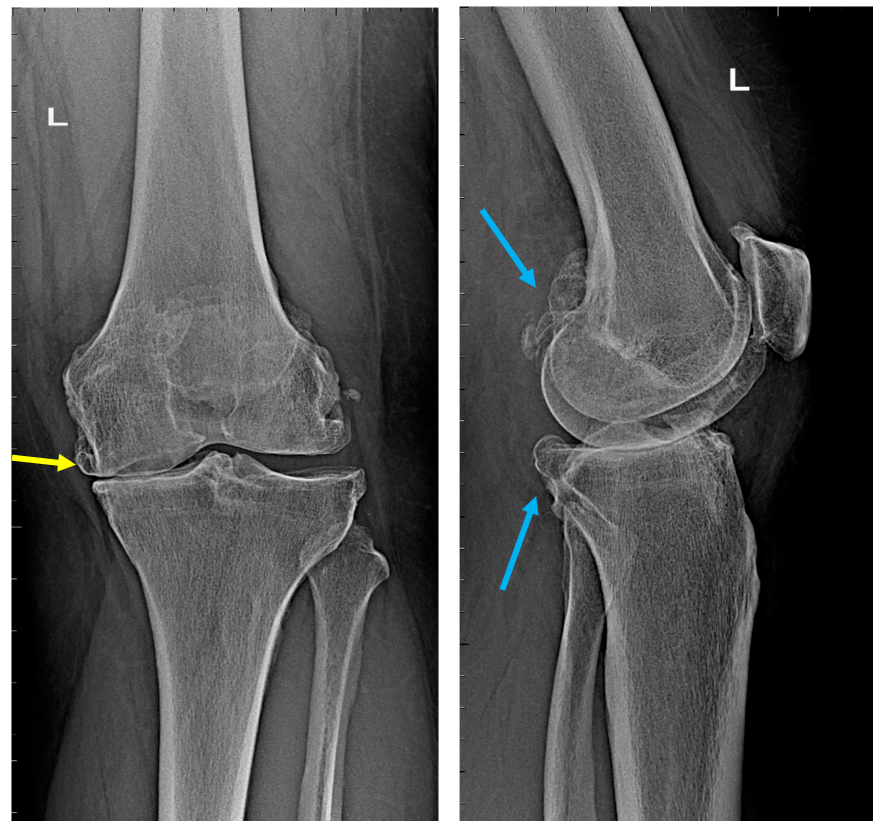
Radiographs of the knee joint. Grade-4 arthrosis on the K–L scale, grade 3 on the Croft–Lane scale. Left—AP view, right—lateral view. Visible (yellow arrow) complete narrowing of the joint space in the medial compartment, numerous osteophytes (blue arrows), and joint-axis disorders. Upper part: femoral bone, lower part: tibia and fibula. Source: proprietary material.
